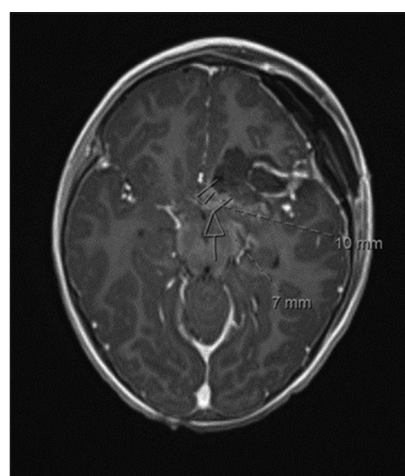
Postoperative magnetic resonance imaging the day following surgery demonstrating expected interval operative changes.
